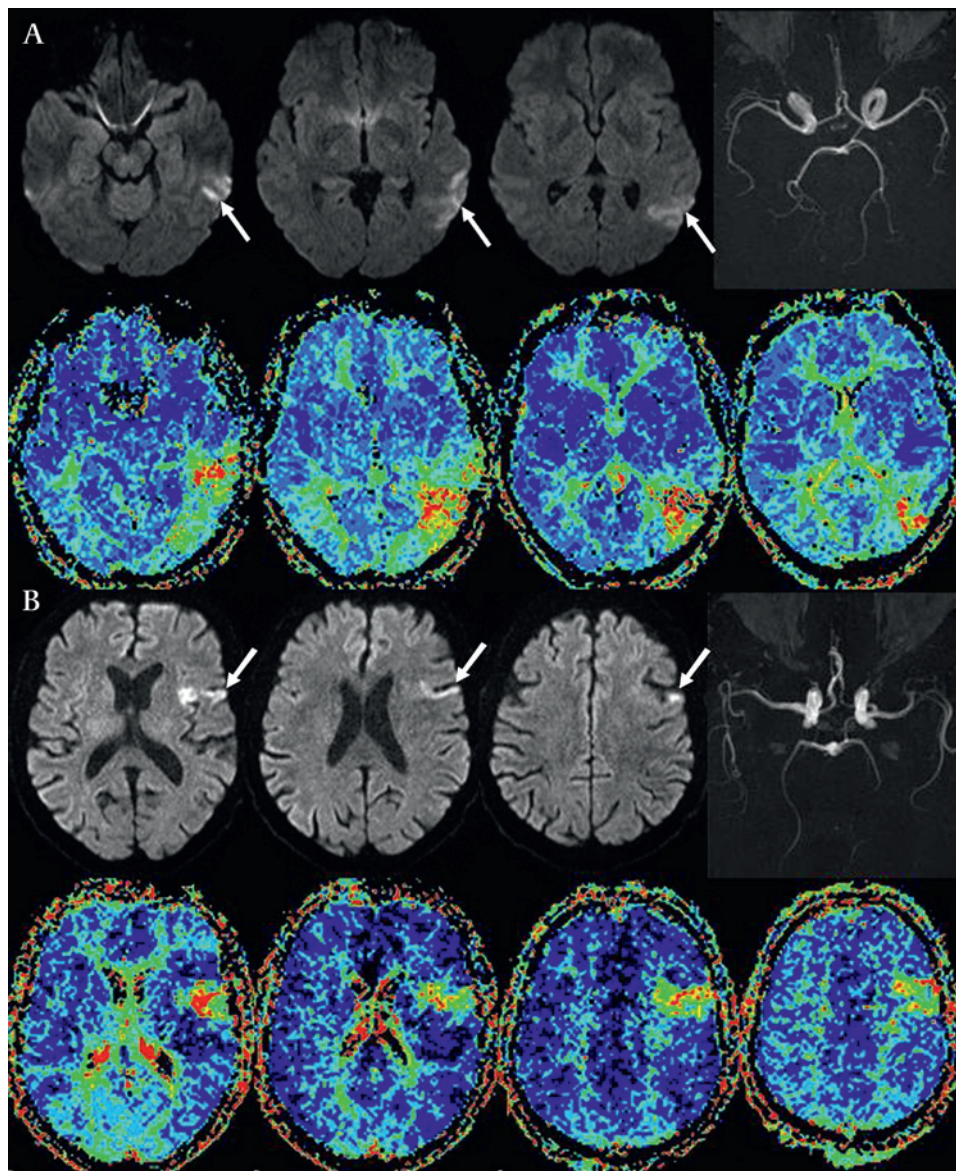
(A) Patient 1: 39-year-old man with Wernicke area lesion on diffusion-weighted-imaging (DWI, arrows). (B) Patient 2: 63-year-old man with Broca area involvement on DWI (arrows). Both patients showed a significant DWI perfusion (time-to-peak maps) mismatch on MRI, prompting intravenous thrombolysis despite minor isolated aphasia. Perfusion imaging confirmed in both patients a distal branch occlusion of the left middle cerebral artery not readily visible on MRA.
